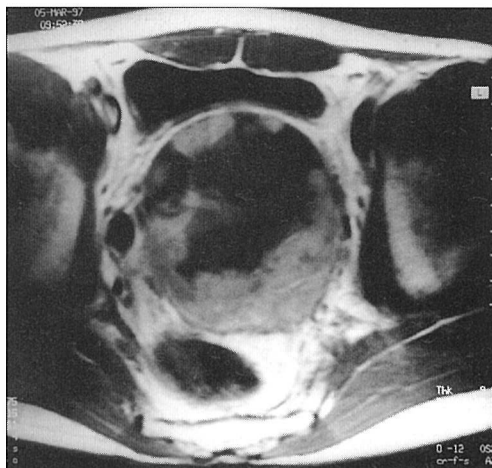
T1-weighted image of tumor: After the injection of contrast medium, the signal in the tumor core is hypointense, whereas in the periphery the signal is mildly hyperintense.
